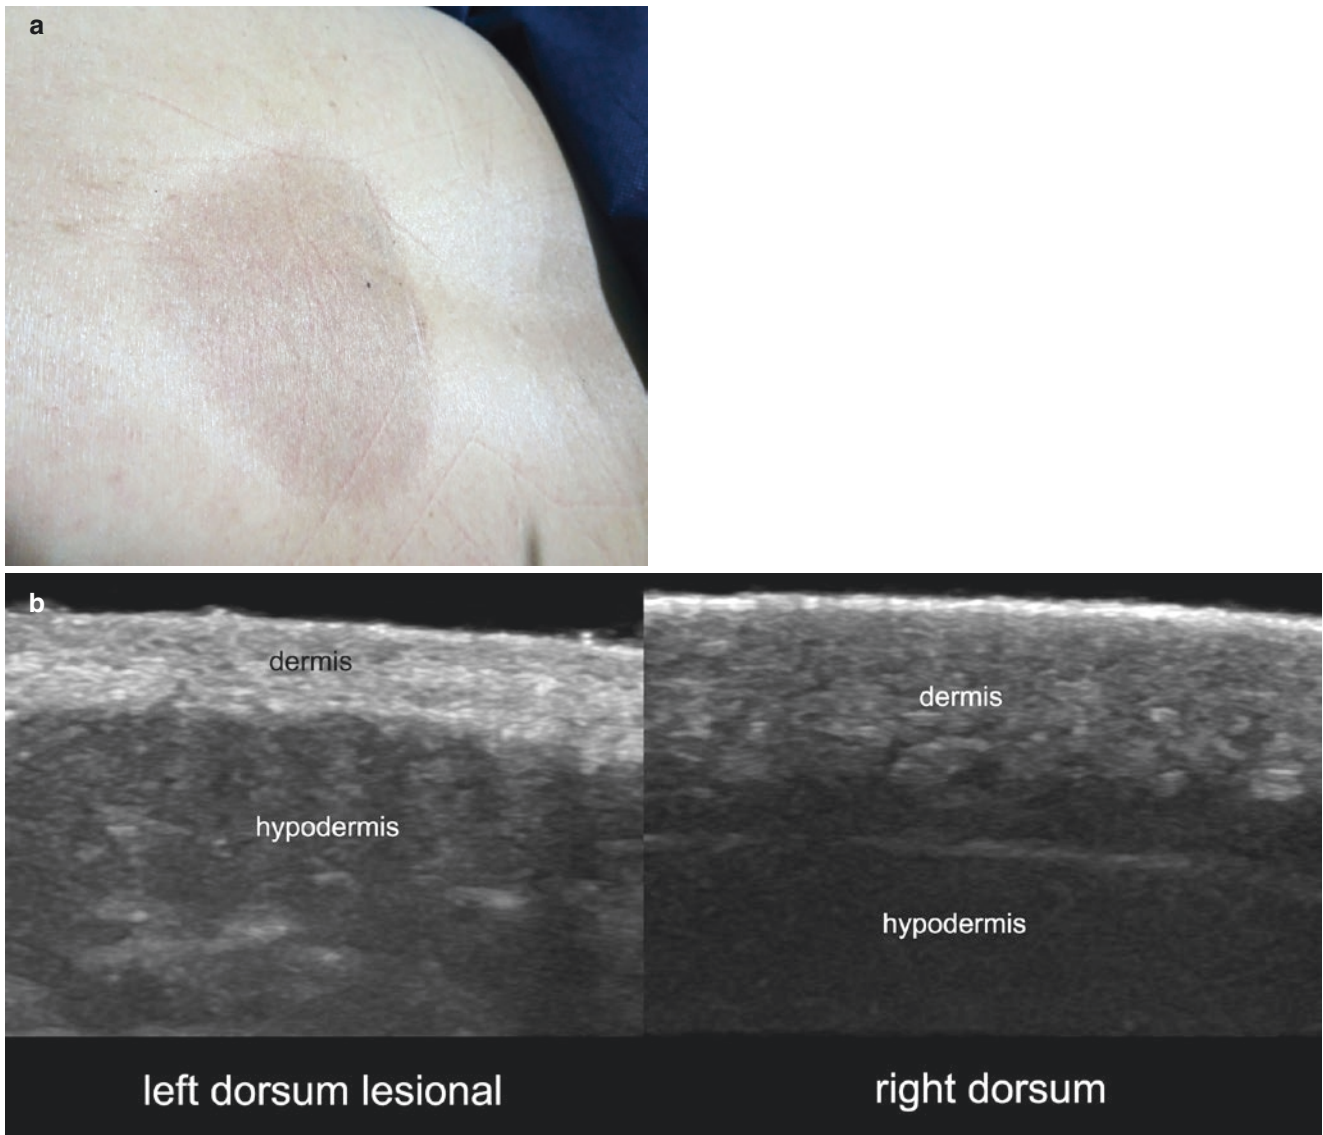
Inactive atrophic morphea. (a) Clinical image. (b) Ultrasound (greyscale; comparative side-by-side transverse views of the dorsal region; left, lesional; right, normal) demonstrates decreased thickness and increased echogenicity of the dermis at the lesional site. Notice that
